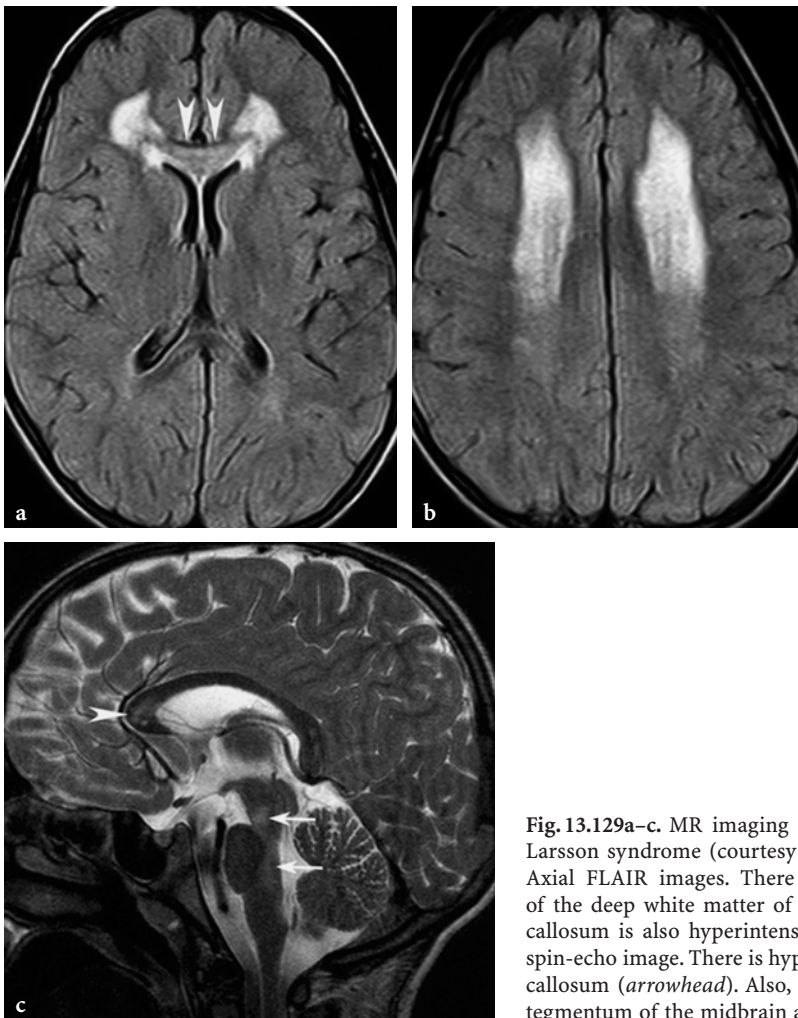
MR imaging findings in a 7-year-old boy with Sjögren-Larsson syndrome (courtesy of Dr. P. Tortori-Donati, Genoa, Italy). a, b. Axial FLAIR images. There is prominent, symmetrical hyperintensity of the deep white matter of both frontal lobes. The genu of the corpus callosum is also hyperintense (*arrowheads*). c Sagittal T2-weighted fast spin-echo image. There is hyperintensity at level of the genu of the corpus callosum (*arrowhead*). Also, faint hyperintensity is suggested within the tegmentum of the midbrain and pons (*arrows*)
